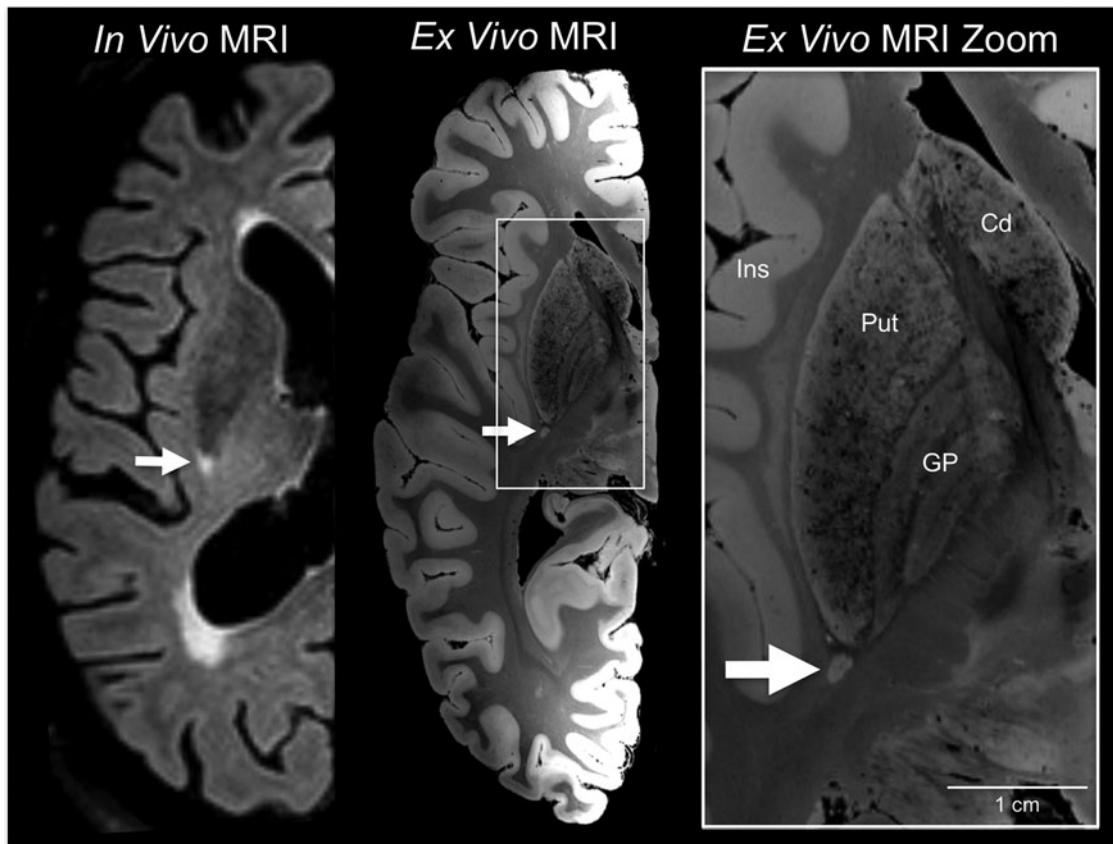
White matter lesion identification on *in vivo* 3 Tesla magnetic resonance imaging (MRI) and *ex vivo* 7 Tesla MRI. An *in vivo* 3 Tesla MRI performed at age 88, after the patient's fifth TBI, revealed bihemispheric corona radiata and internal capsule white matter hyperintensities, including a punctate lesion at the posterior aspect of the putamen (arrow). The same lesion was identified by *ex vivo* 7 Tesla MRI (arrow), which was performed on the formalin-fixed right hemisphere. A zoomed view of the lesion is shown in the right panel (arrow) to demonstrate the increased anatomic precision provided by *ex vivo* MRI (200 μm resolution) for delineating the borders of the lesion with respect to nearby anatomic structures. Cd, caudate; GP, globus pallidus; Ins, insula; Put, putamen.
